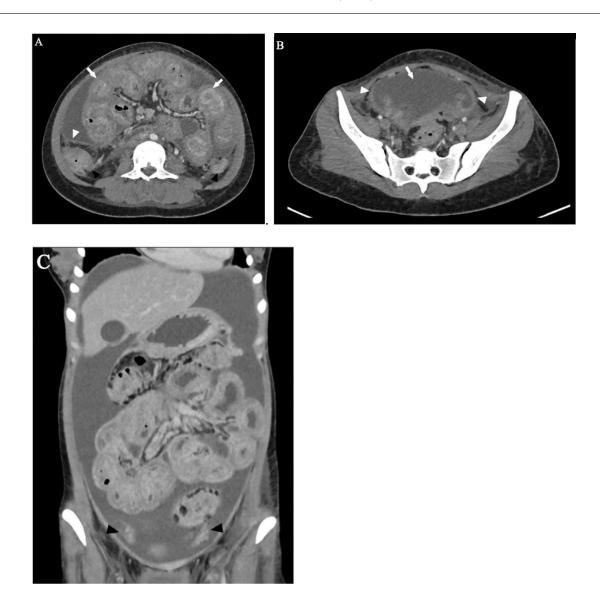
Axial (A, B) and coronal post-contrast abdominopelvic CT images: Small bowel loops and loculated fluid are positioned centrally (white arrow in A and B) are encased by a thick enhancing extra-peritoneal membrane that extends down to the pelvis (white arrowheads in A and B). The ascending and descending colon are not involved (black arrowheads in A). The ovaries are within the encasement (black arrowheads in C).
